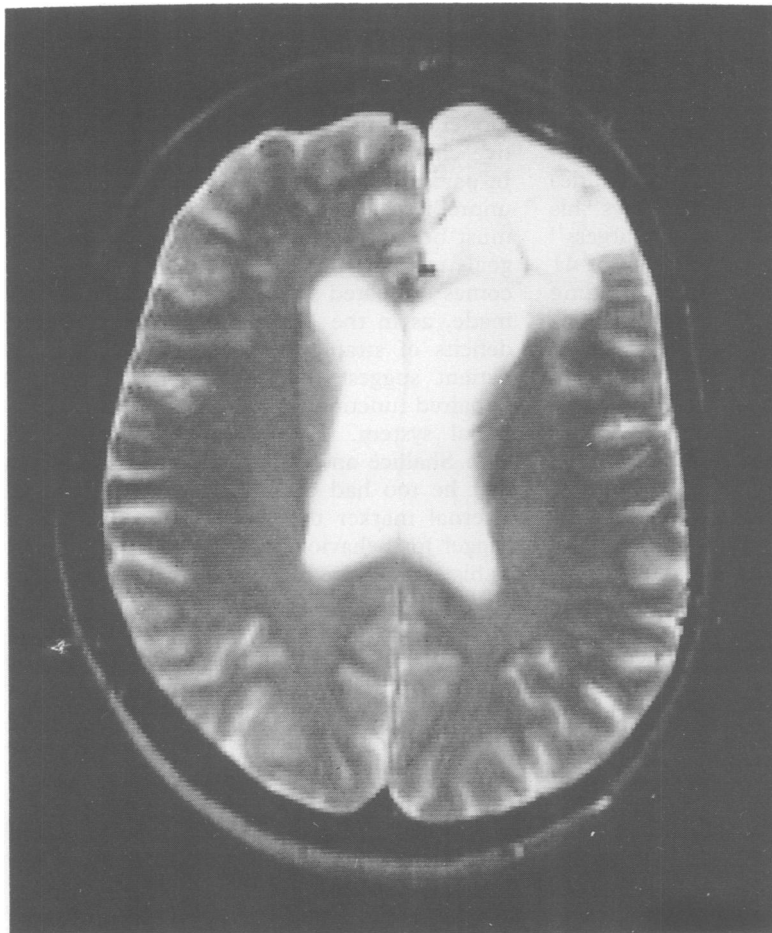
weighted MRI scan (SE TR 3.2 s TE 80 ms) showing extent of left frontal lobectomy.
